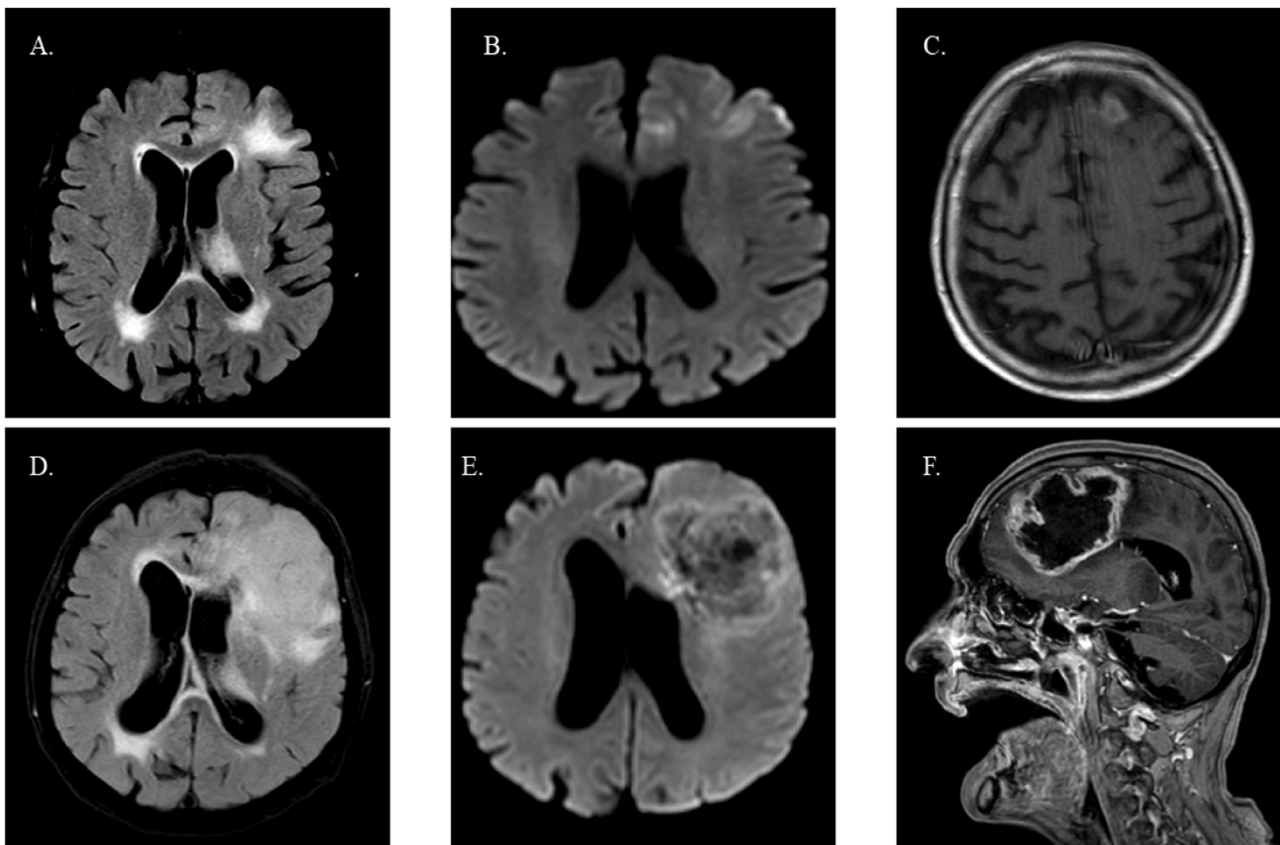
Initial and follow-up MRI images of patient 2.
